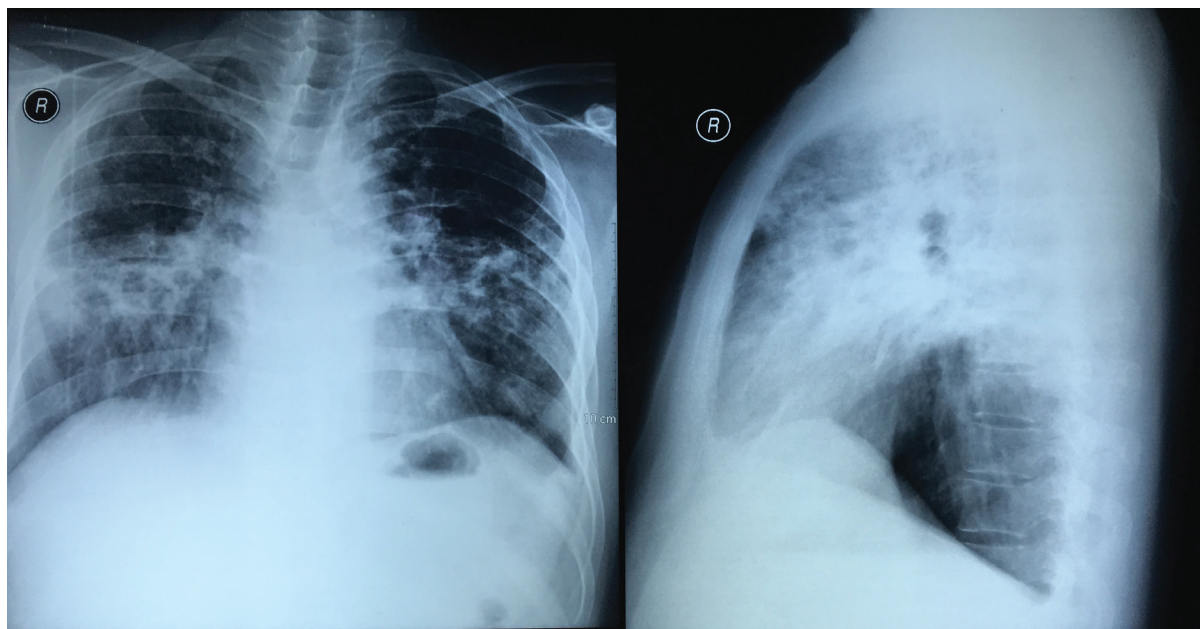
(a) Chest x-ray on the first day and (b) the third day
